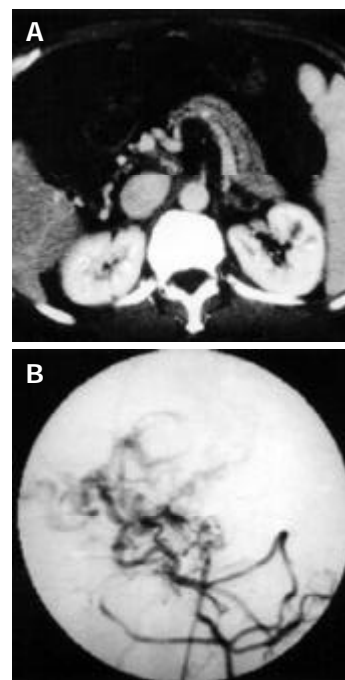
Main portal vein occlusion, hepatic arteric portal shunt and portal cavernous transformation in a 64-year-old patient with refractory ascites and hematemesis. A: Thin splenic and superior mesenteric vein shown on enhanced CT gram. B: Thin superior mesenteric vein and disordered drainage vein shown on angiogram.
